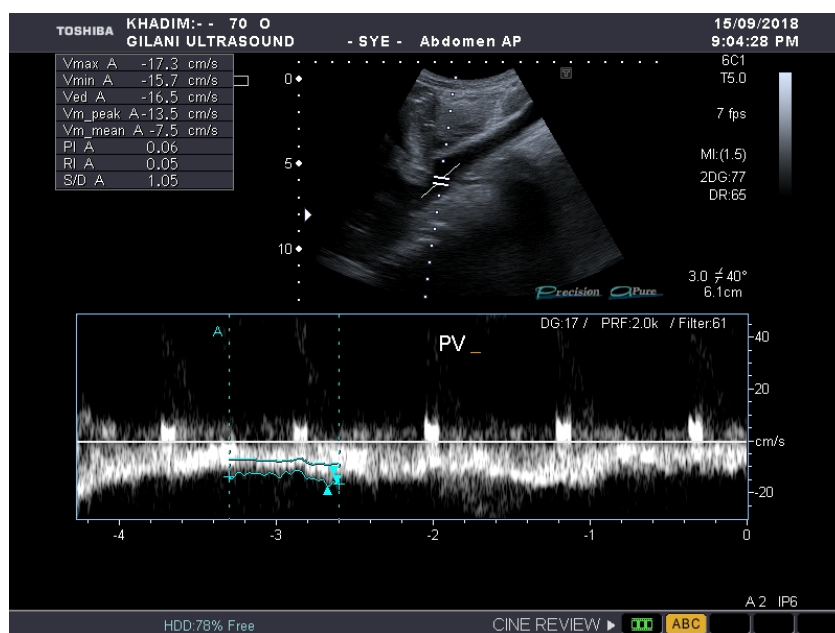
Ultrasound image showing a normal congestive index of the portal vein.
